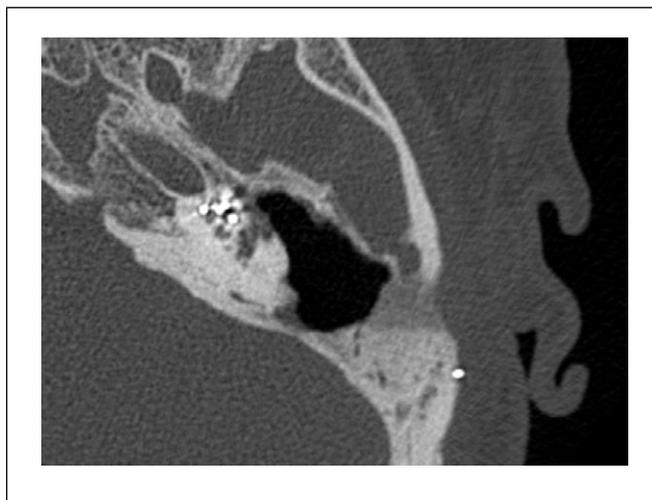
CT of the left temporal bone of the patient 12 months after the surgery. The postoperative cavity is without pathological contents. There are no signs of recurrence of cholesteatoma and electrode extrusion.
